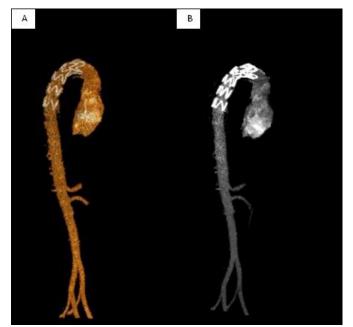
A, B: VR and MIP reconstruction of postoperative CT angiography with stent graft.
